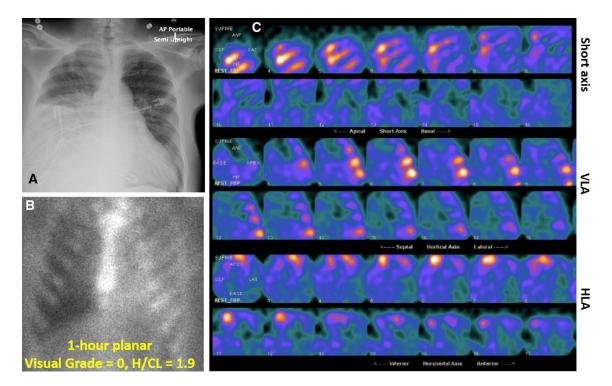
Erroneous elevation in heart-to-contralateral ratio in a patient with large right pleural effusion. Chest x-ray (A), demonstrating a large right pleural effusion. Anterior planar PYP image (B) depicting no cardiac PYP activity, which is confirmed on PYP SPECT (C).
